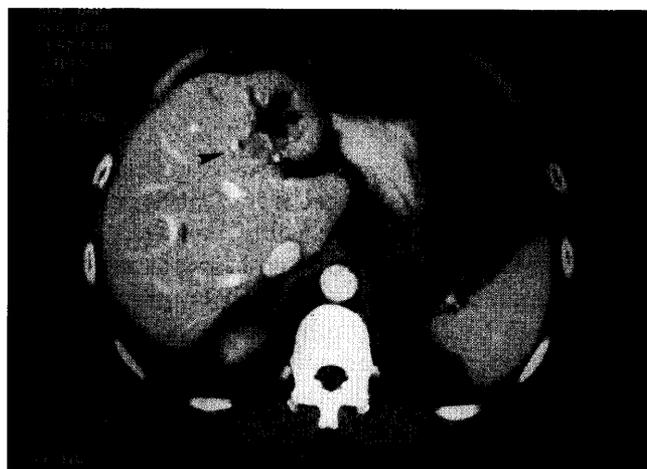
Patient presenting with fever and jaundice. CT scan showing selective left intrahepatic ductal dilatation with a filling defect within the duct.
